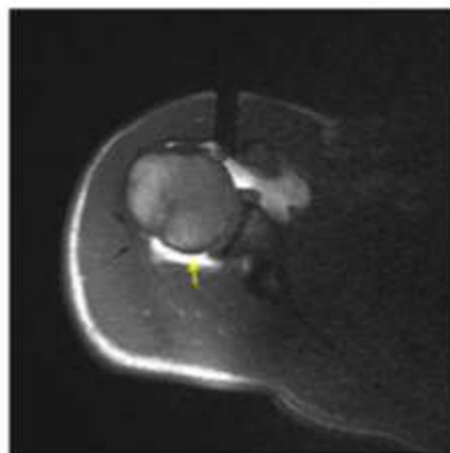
Real-time T1-weighted image demonstrates the injected gadolinium
